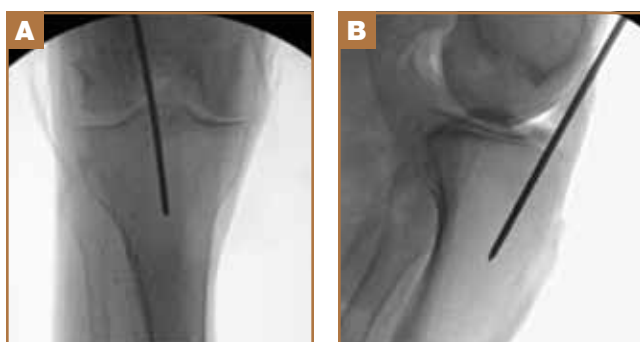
AP radiograph (A) and lateral radiograph (B) using standard techniques, with the fibular head bisected on the AP view, and the femoral condyles aligned on the lateral view.
